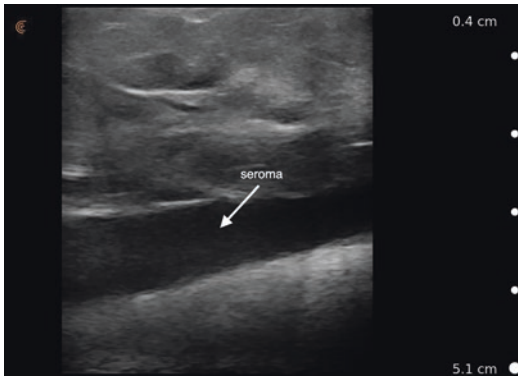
Grayscale ultrasound image of a seroma of the anterior abdominal wall
